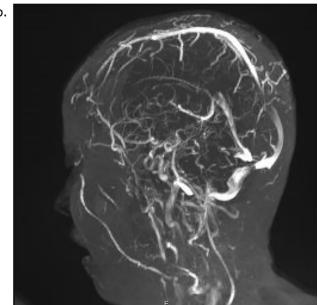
(a) Cranial MRI. (b) MR venography.
